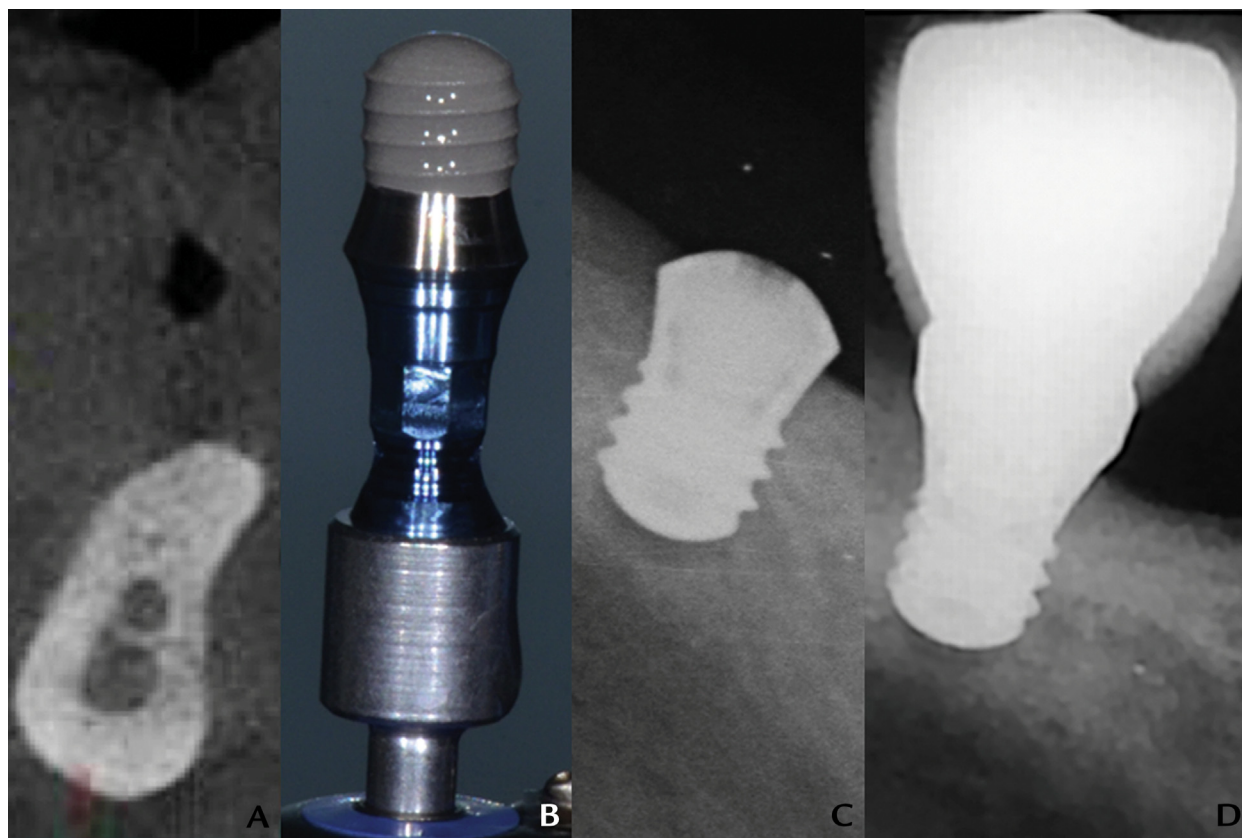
Initial situation and subsequent follow-up visits. A, Bone remnant available. B, Regular diameter 4.1-mm extra-short implant. C, Radiograph after osseointegration. D, Radiograph after definitive restoration (baseline).
